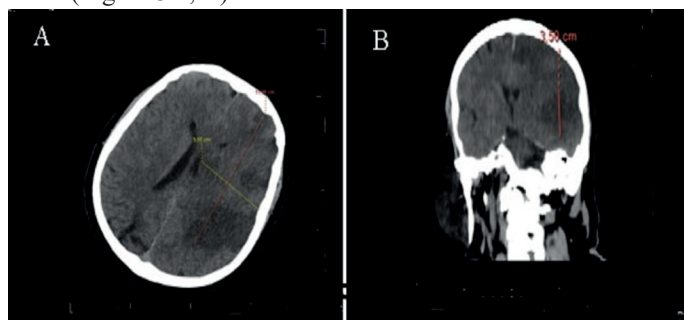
Preoperative brain computed tomography images showing left middle cerebral artery infarction measured using the ABC/2 method. (A) axial scan, (B) coronal scan
